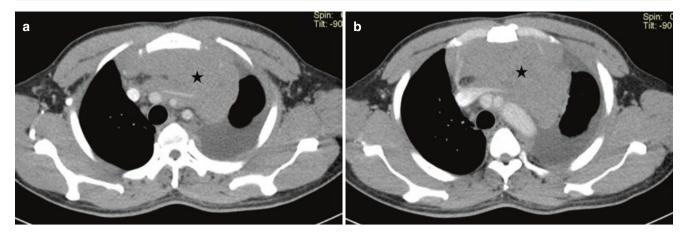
Lymphoma in the anterior mediastinum. (a, b) Axial CT images show a homogeneous mass (asterisk) with mass effect on the vessels without invasion. There is left pleural effusion
